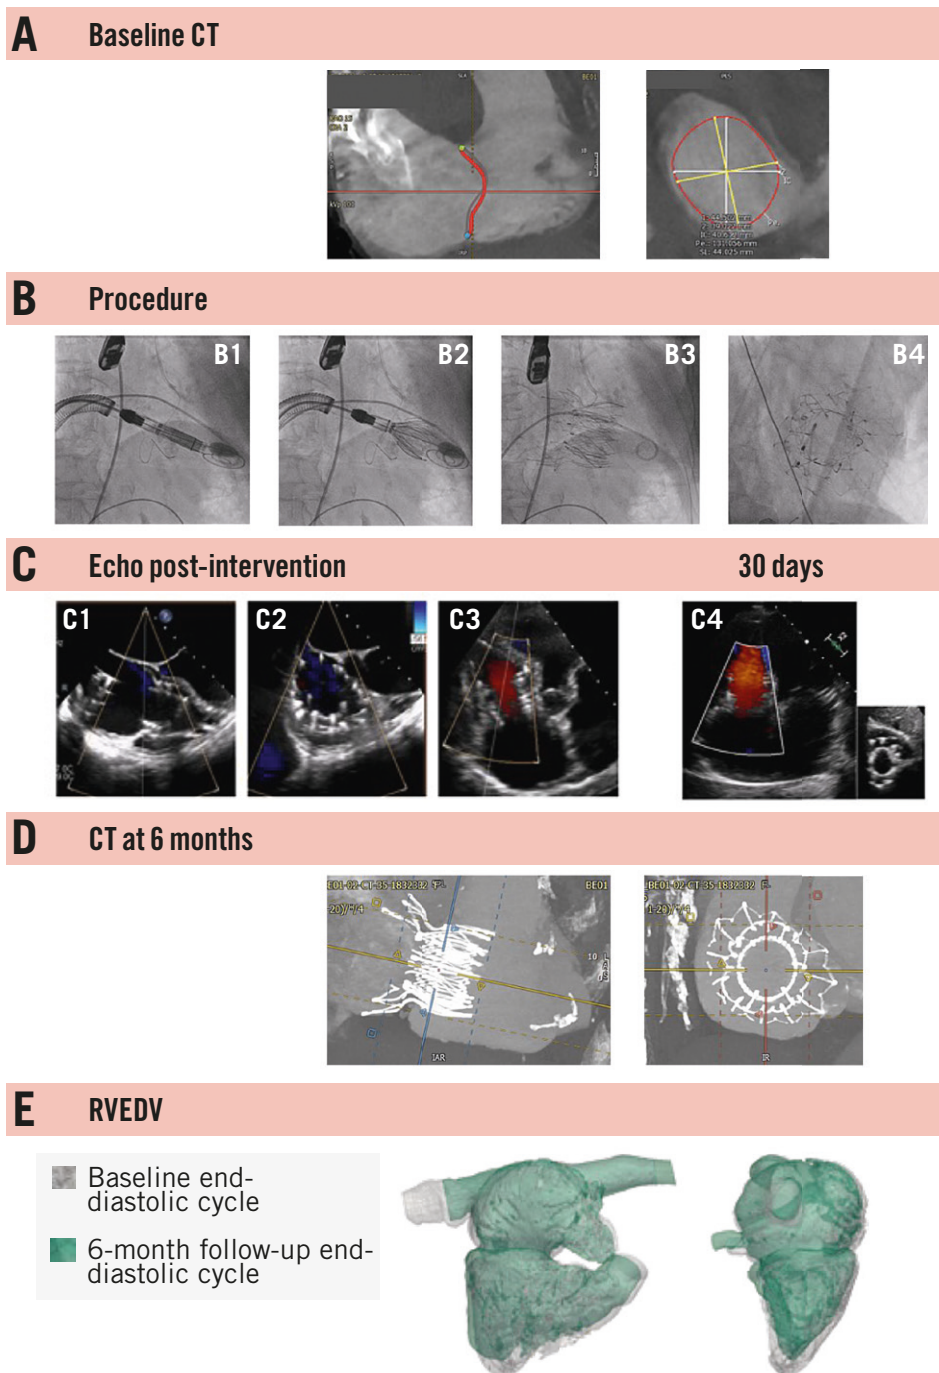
Exemplary case report with echocardiographic and computed tomography assessments. Exemplary case report of a 78-year-old female. A) Baseline computed tomography (CT) revealed an oval-shaped annulus in systole, delineated by a red line, with a minimum diameter of 42 mm and a maximum diameter of 45 mm. B1) Using a steerable sheath, the valve was advanced towards the right ventricle. The wire in the right coronary artery served as a landmark for the tricuspid annulus during positioning. B2) The delivery sheath was partially retracted, allowing for the assessment of valve height and perpendicular alignment with the annulus using multiplanar transoesophageal imaging. B3) After confirming the valve position, the valve was deployed from bottom to top under fast pacing. B4) Final angiography demonstrated excellent results: no residual leakage, a circular inner ring/stent, and an outer ring well-conformed and adapted to the anatomical annular shape in the en face view. C1-C3) Postprocedural results by transoesophageal echocardiography and (C4) transthoracic echocardiography on day 30 post-procedure. D) CT imaging at the 6-month follow-up confirmed the persistent round shape of the inner ring and continued conformity of the outer ring to the annulus. E) The right ventricular end-diastolic volume (RVEDV) decreased by 19%, from 175 mL at baseline to 142 mL at 6 months, as assessed by the core laboratory.
